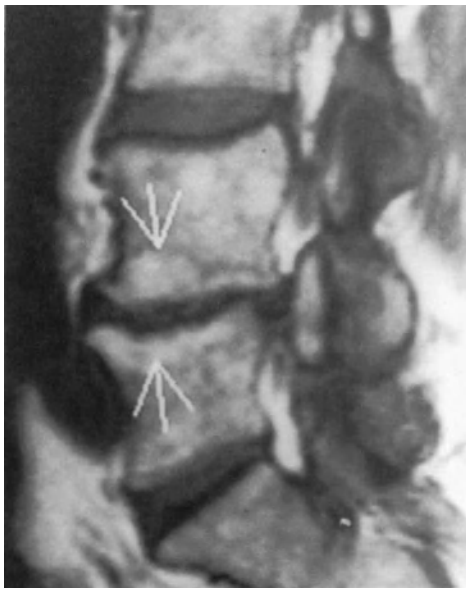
Spin-echo T1-weighted MR image. Hyperintensity of the subchondral bone of the L4 and L5 vertebral bodies (arrows) due to Modic's et al. (141) Type II changes of the subchondral bone marrow.
